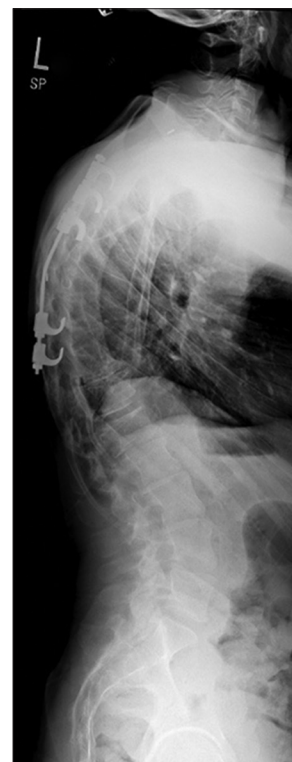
Standing posteroanterior (left) and lateral (right) scoliosis plain films. There is a right-side scoliotic curve from T8 to L3 (apex at T12) of 31° and thoracic kyphosis from T3 to T12 of 82°. The size of the thoracic vertebral bodies appears small given the size of the lumbar vertebral bodies, and the thorax is proportionally small.
